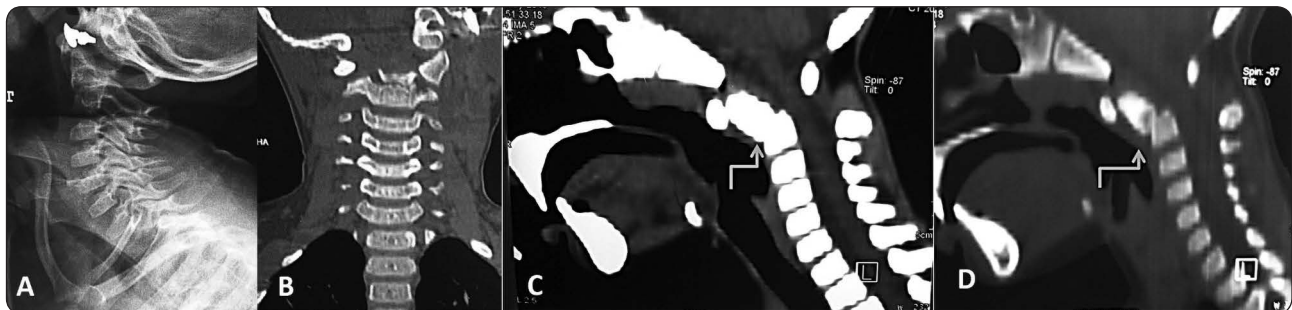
(A) Plain radiograph of the cervical spine, lateral view showing angulation and forward displacement of the odontoid process. (B) CT scan of the cervical spine, coronal view showing line of separation of the dens. (C,D) CT scan of the cervical spine with sagittal reconstruction showing same finding.
